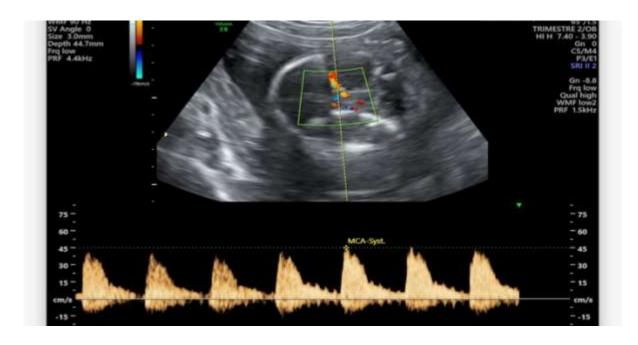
Middle cerebral artery Doppler velocimetry at 23 weeks gestation showing a peak systolic velocity of 1.6 MoM.
